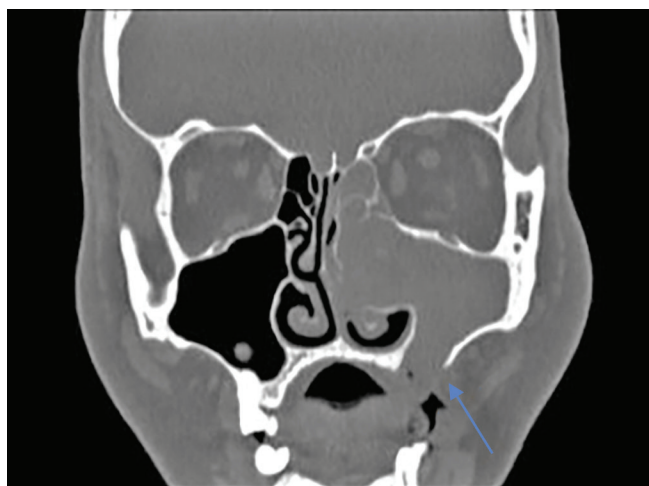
Plain CT PNS coronal view showing defect in the left maxillary sinus floor with a soft tissue opacity in the entire maxillary sinus and left nasal cavity
